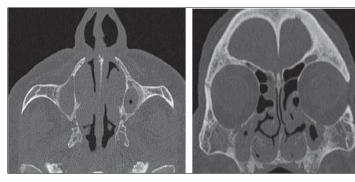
Axial section (left) and coronal reconstruction (right) of a patient's sinus CT scan showing framed mucosal thickenings of the maxillary sinuses with osteosclerosis of the sinus walls consistent with bilateral chronic maxillary sinusitis.
